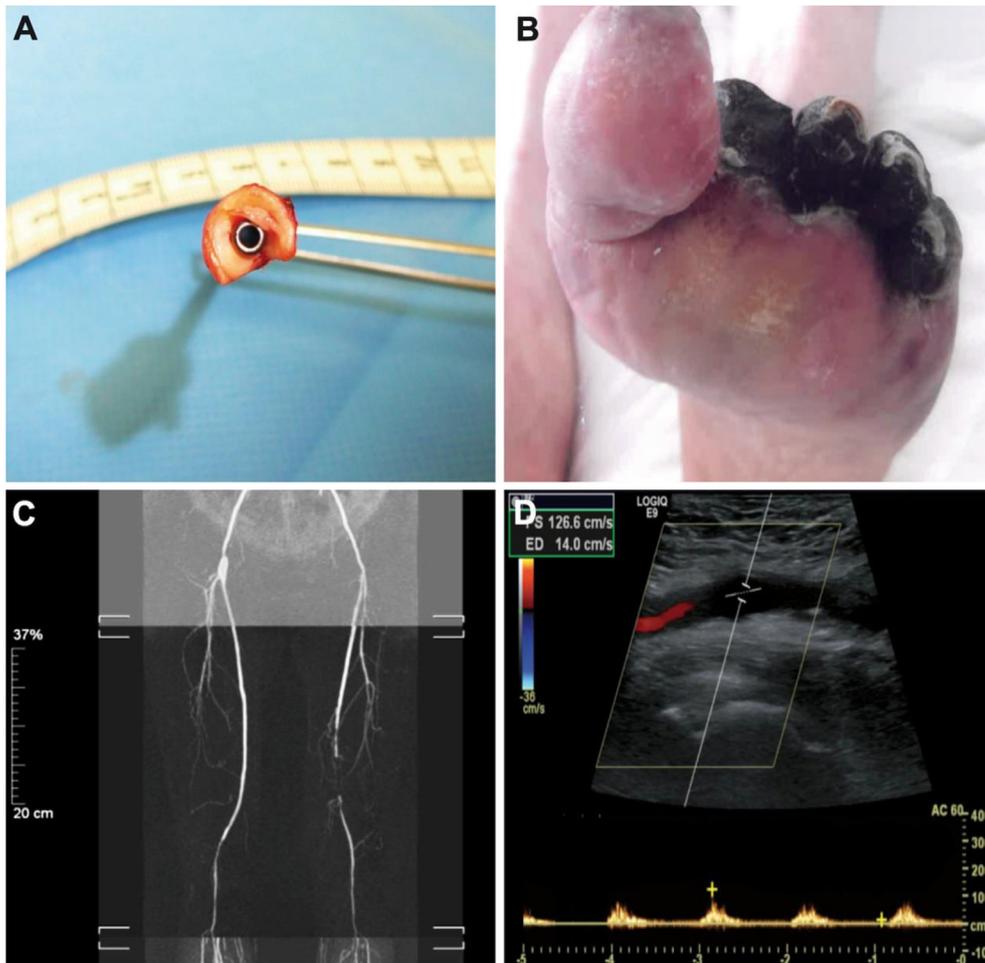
A) Typical circular stenosis in a resection of the superficial femoral artery of a patient with severe Lp(a)-HLP. In contrast to plaques in patients with “common” atherosclerosis, the plaques in patients with Lp(a)-HLP often exhibit a circular shape, with no ulcerations, little or no calcification and a homogeneous internal structure. The circular stenoses range over long distances. (B) Clinical presentation of a patient with Lp(a)-HLP and PAD stage IV. (C) Typical MR-angiogram with a total occlusion of the left superficial femoral artery over a distance of 15 cm and the typical small lumen vessels. (D) In patients with Lp(a)-HLP duplex ultrasound typically exhibits thin lumen vessels without distinct plaques and only little echo contrast (example shows the right common femoral artery).
